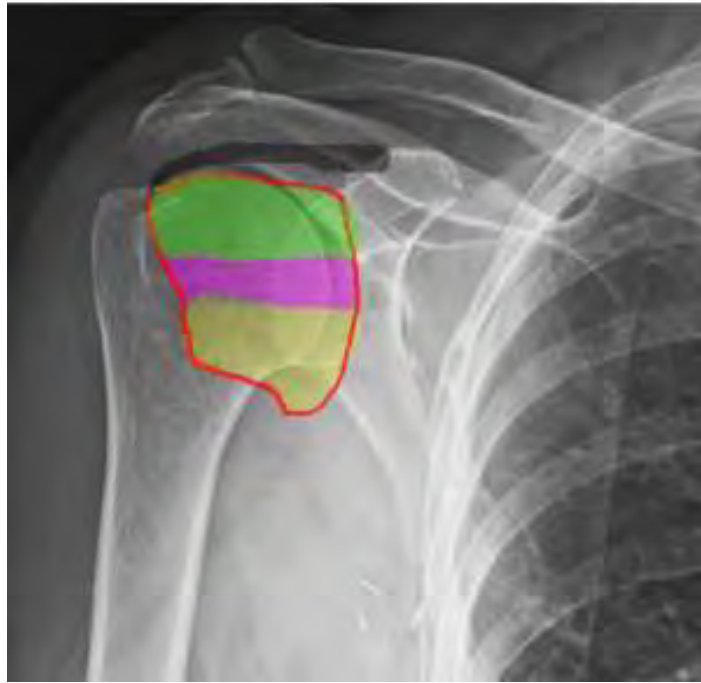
The ligaments connecting the humerus to the scapula. The coracohumeral ligament is shown in faint black; the capsule is outlined in red. The capsule itself comprises the superior (green) middle (pink) and inferior (yellow) glenohumeral ligaments. (Annotations on x-ray courtesy of <https://radiopaedia.org/cases/external-and-internal-rotation-views-of-the-shoulder>)
